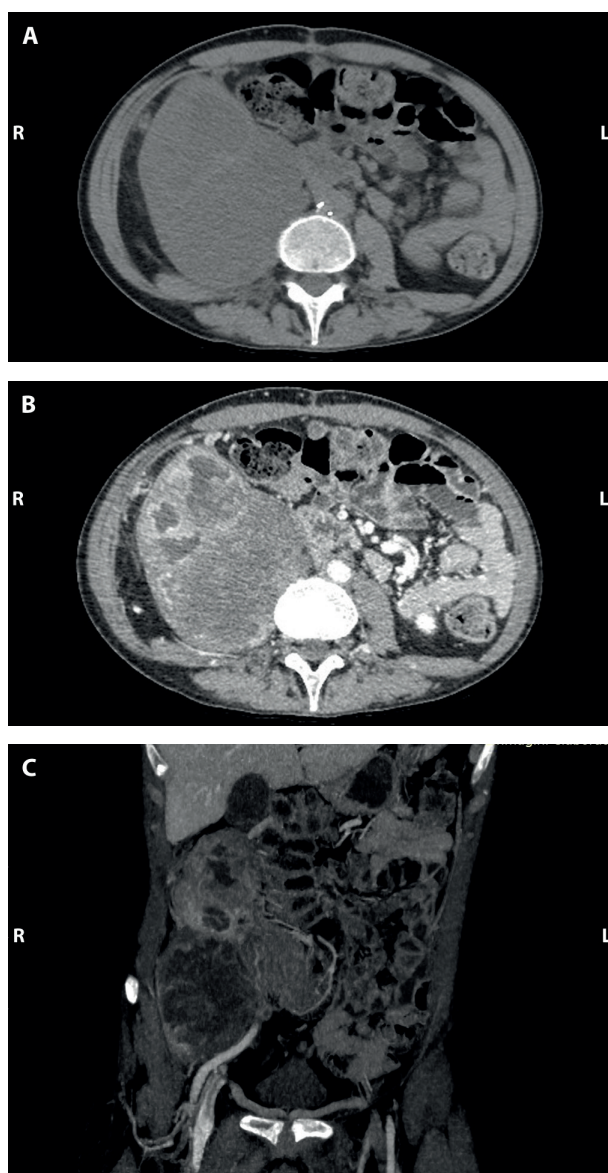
Last CT scans show an enlargement of the mass which occupies the entire right lumbar region and reaches the inferior border of liver. (A): axial unenhanced CT scan, (B): axial enhanced CT scan shows necrotic-colliquative areas within the mass, (C): coronal enhanced CT scan shows the extension of the lesion till the inferior border of the liver.
